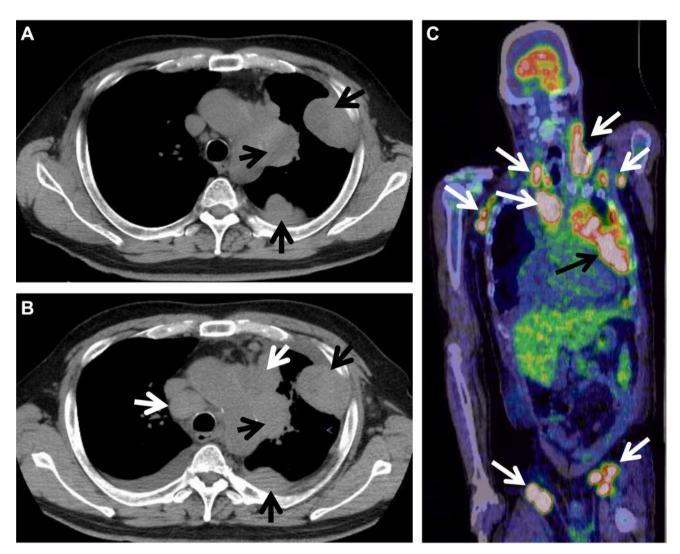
A: Chest computed tomography showing nodules in contact with the left pleura (arrows), indicating disseminated lesions due to thymic cancer. B: Chest computed tomography revealing nodules arising from thymic cancer (black arrows) and marked mediastinal lymphadenopathy (white arrows). C: 2'-Deoxy-2'-[<sup>18</sup>F] fluoro-D-glucose positron-emission tomography revealing increased accumulation in the cervical, axillary, mediastinal and inguinal regions (white arrows) and nodules secondary to thymic cancer (black arrow).
